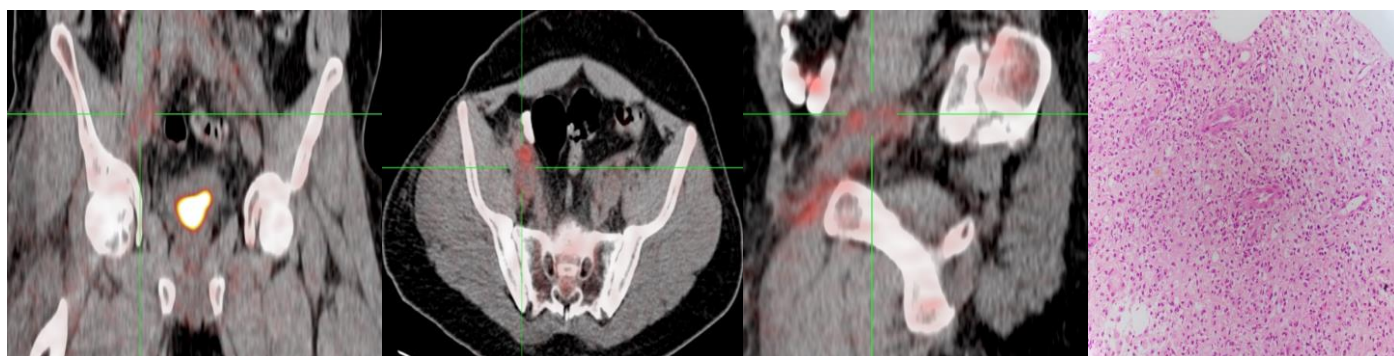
26 years old male patient referred to FDG PET/CT for investigation of inflammation, infection or vasculitis. The imaging verified the clinical condition as vasculitis of the vena cava as well as right common iliac femoral vessels inflammatory FDG accumulation and thrombosis. Pathology results confirmed inflammation.
